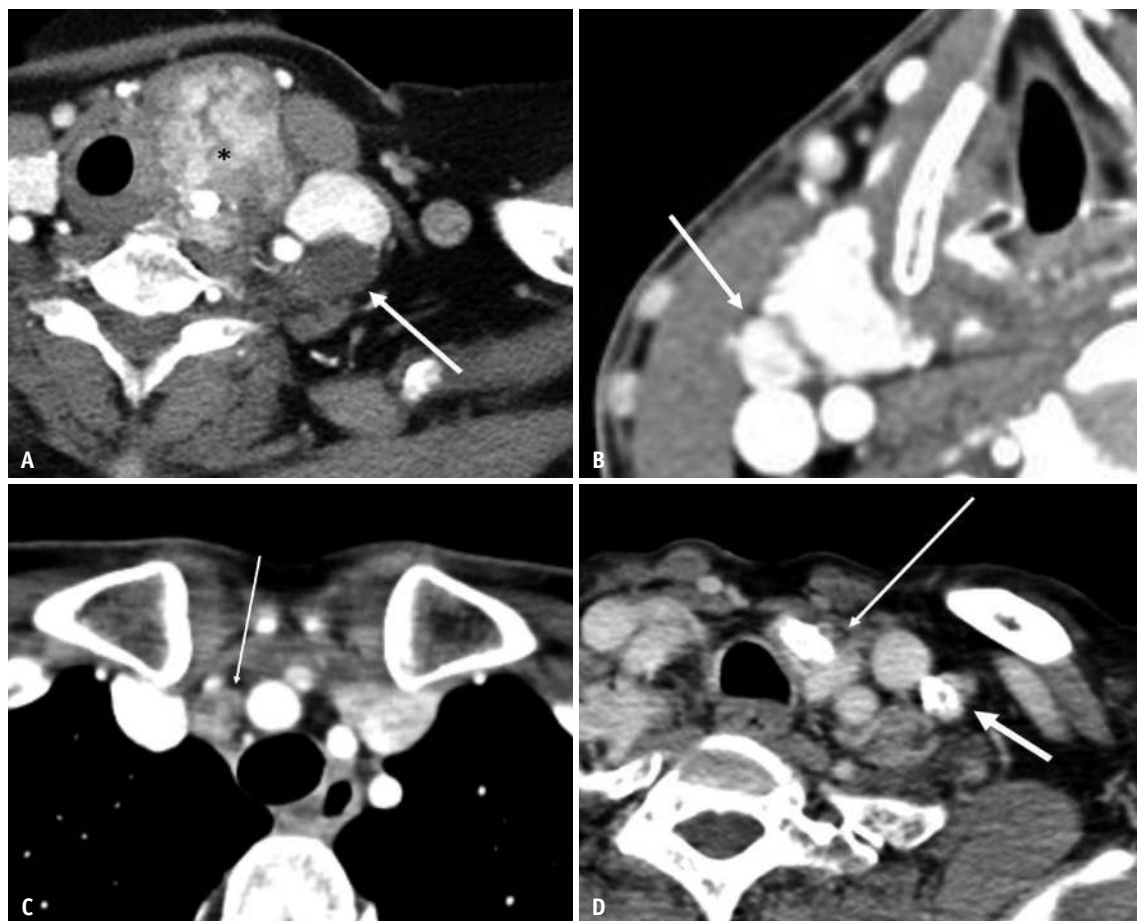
Suspicious lymph nodes on CT.
